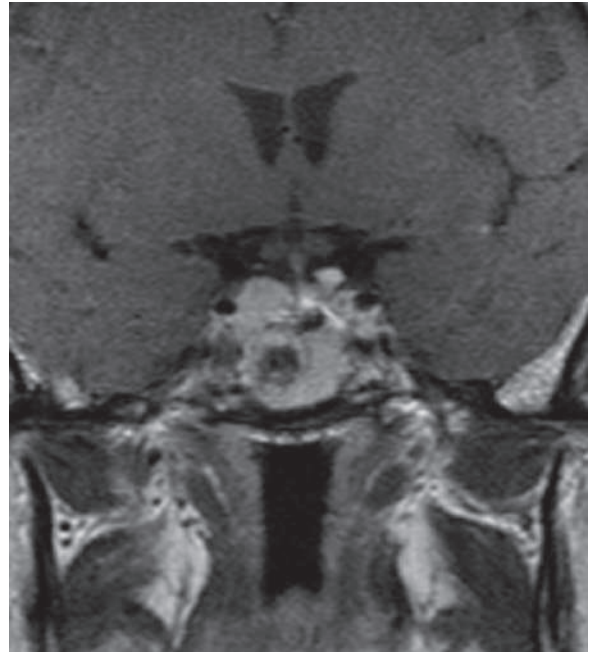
Coronal T1W postcontrast MRI of the sellas shows large pituitary adenoma with inner cystic changes and infiltration of the left cavernous sinus in a patient with Nelson's syndrome. The patient had bilateral adrenalectomy in 1994, and he developed pituitary adenoma in 2006
